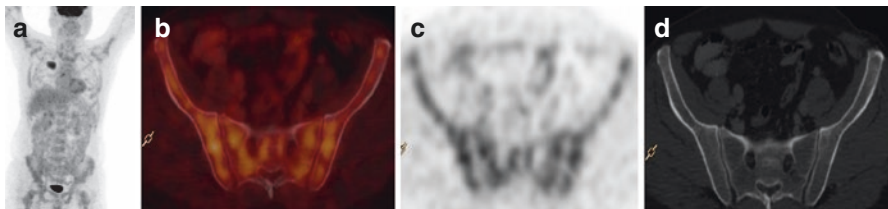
Whole-body FDG PET/CT scan in a 61-year-old gentleman with adenocarcinoma in the right lung (MIP image a) with diffuse increased FDG uptake in the axial and appendicular skeleton seen in MIP image (a) and transaxial images of the pelvis (b–d) due to anemia. The hemoglobin was 8 g/dL [normal range, 13–17 g/dL]
